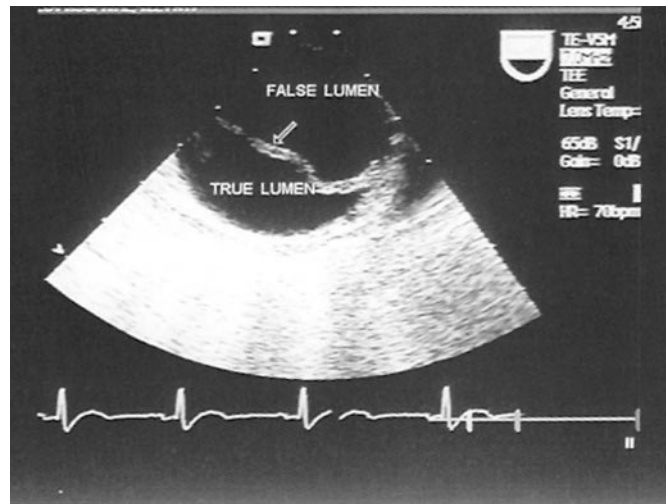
Transesophageal echocardiographic image clearly demonstrating the protruding aortic false lumen.
